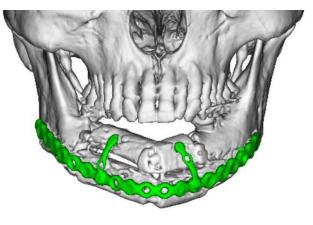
Three-dimensional CT findings at 3 months postoperative.
